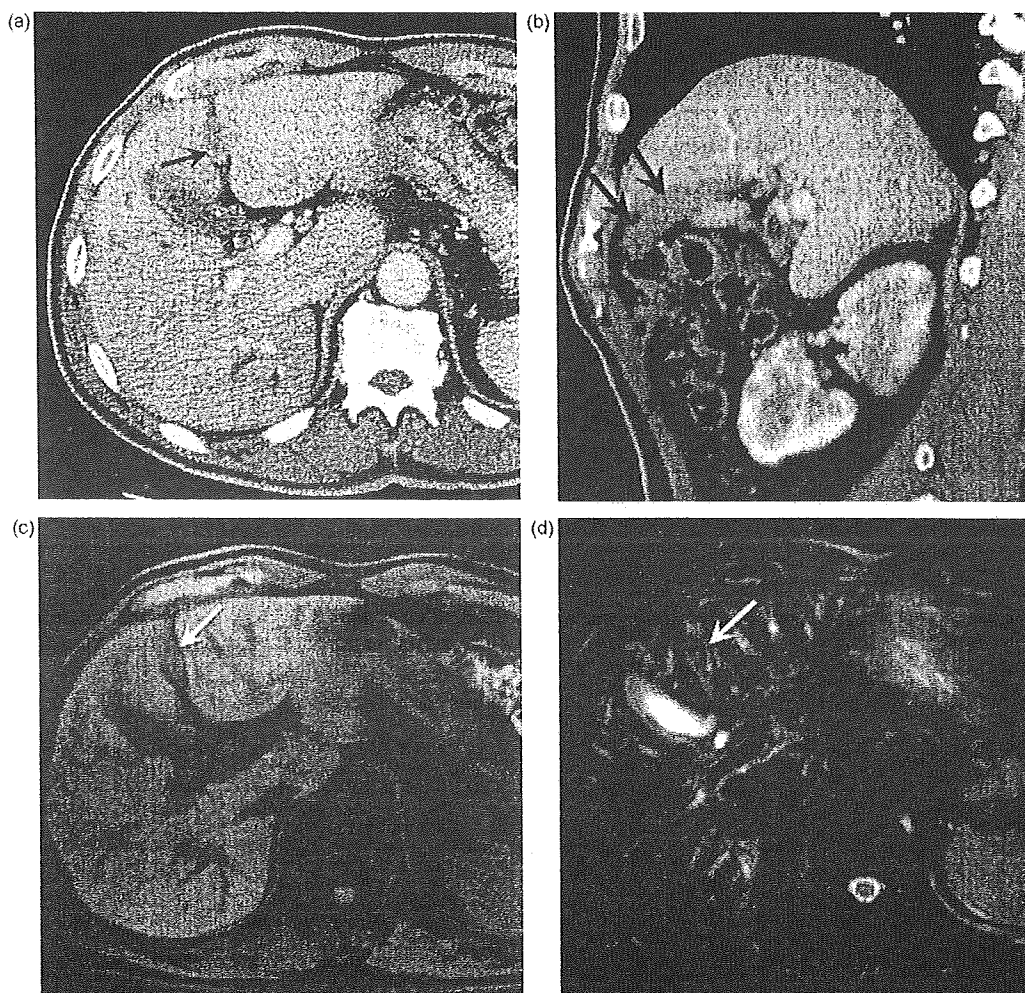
Lesions in the *ligamentum teres*. (a) Contrast-enhanced CT shows soft tissues mass in the *ligamentum teres* (arrow). (b) Saggital image of contrast-enhanced CT shows the spindle-shape mass along *ligamentum teres* (large arrows). (c-d) MR images show hypointense mass on fat saturated T1-weighted images and hyperintense mass on fat saturated T2-weighted images (white arrows).
